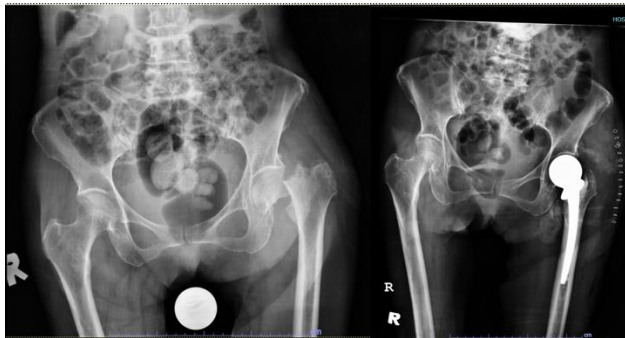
Pre- and post-operative pelvic X-rays.
